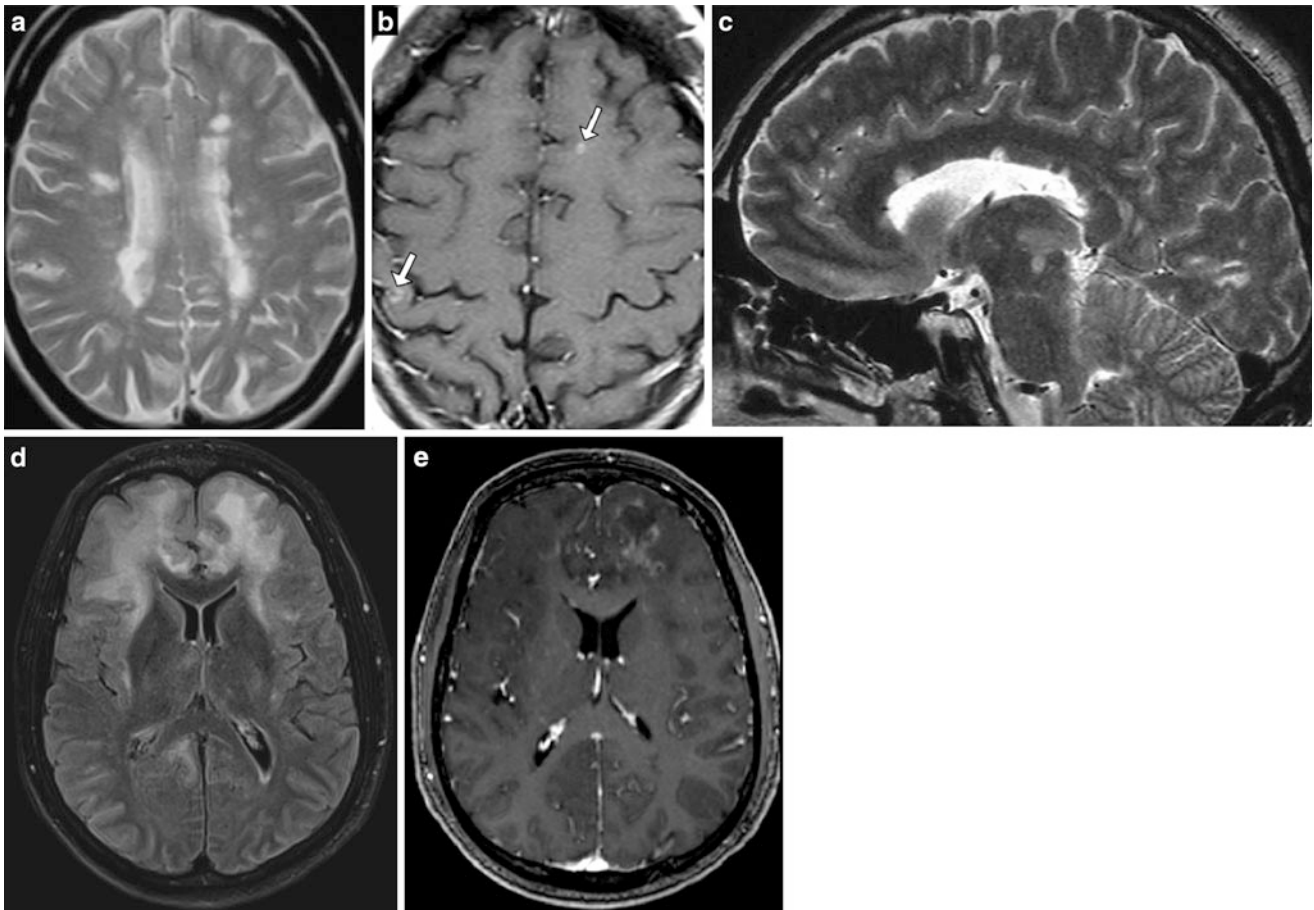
Multiple sclerosis. a Axial T2-weighted image shows multiple bilateral periventricular round or ovoid hyperintensities. b Axial T1-weighted image after contrast administration depicts nodular enhancement as a correlate of active demyelination (arrows). c Multiple sclerosis. c The sagittal T2-weighted image through the midline demonstrates infra- and supratentorial MS plaques and the preferred
